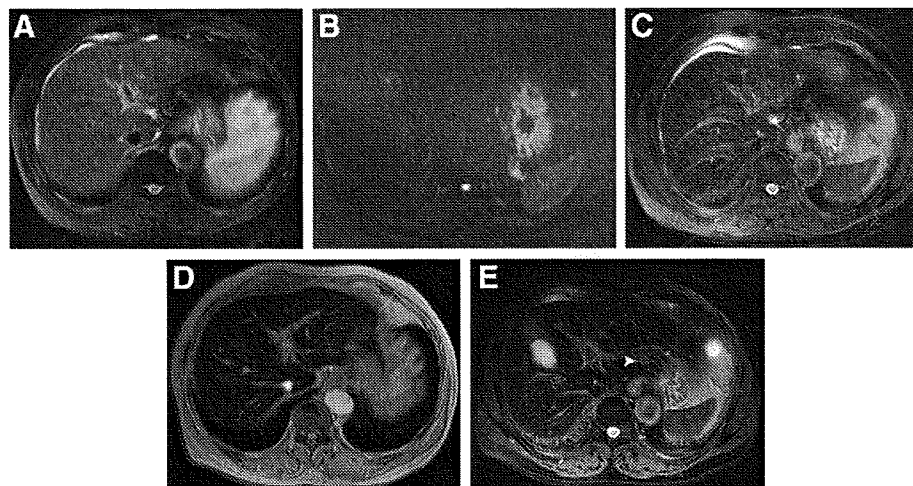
Abdominal images obtained using superparamagnetic iron oxide-enhanced (SPIO) administration in a 48-year-old man with pancreatic cancer. Precontrast (A) fat-saturated T2-weighted TSE (5330/103) and (B) diffusion-weighted GRAPPA (2100/91; b-factor, 1000 seconds/mm²) MR images. Postcontrast (C) fat-saturated T2-weighted TSE with respiratory triggering (PACE), (D) T2*-weighted GRE (169/9, 60 degrees flip angle) and (E) fat-saturated PROPELLER T2-weighted TSE with PACE MR images. The hepatic metastatic lesion is obscure in all images except for that with the PROPELLER sequence (E) because of image artifacts. The 0.9-cm diameter hepatic tumor (arrowhead) in segment II can only be clearly observed using the PROPELLER method (E). Note that the hyperintense subcapsular lesions in segment IV (A, B) and in the right lobe (C, D) were confirmed to be pseudolesions.
